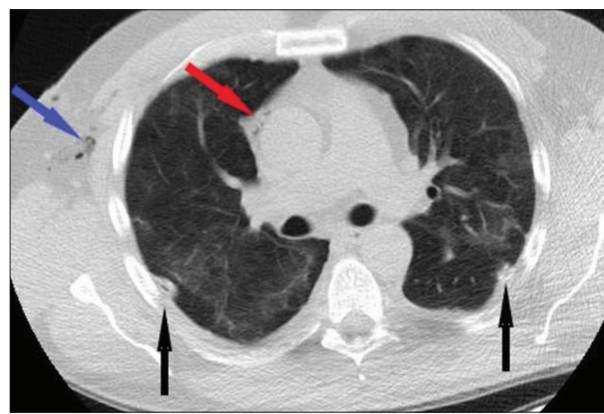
Chest computed tomography scan after bilateral chest tube placement; black arrows show chest tubes; the blue arrow shows subcutaneous emphysema; the red arrow demonstrates the Macklin effect
